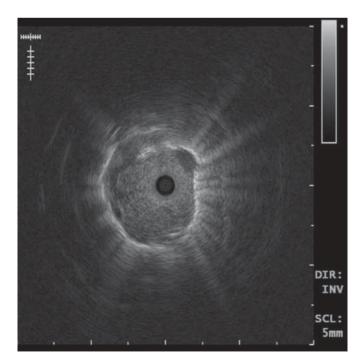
Typical endobronchial ultrasonographic image of a single pulmonary nodule, in this case a nodule of 14 mm in diameter in the left upper lobe of a 53-yr-old male with a suspected diagnosis of lung cancer.
